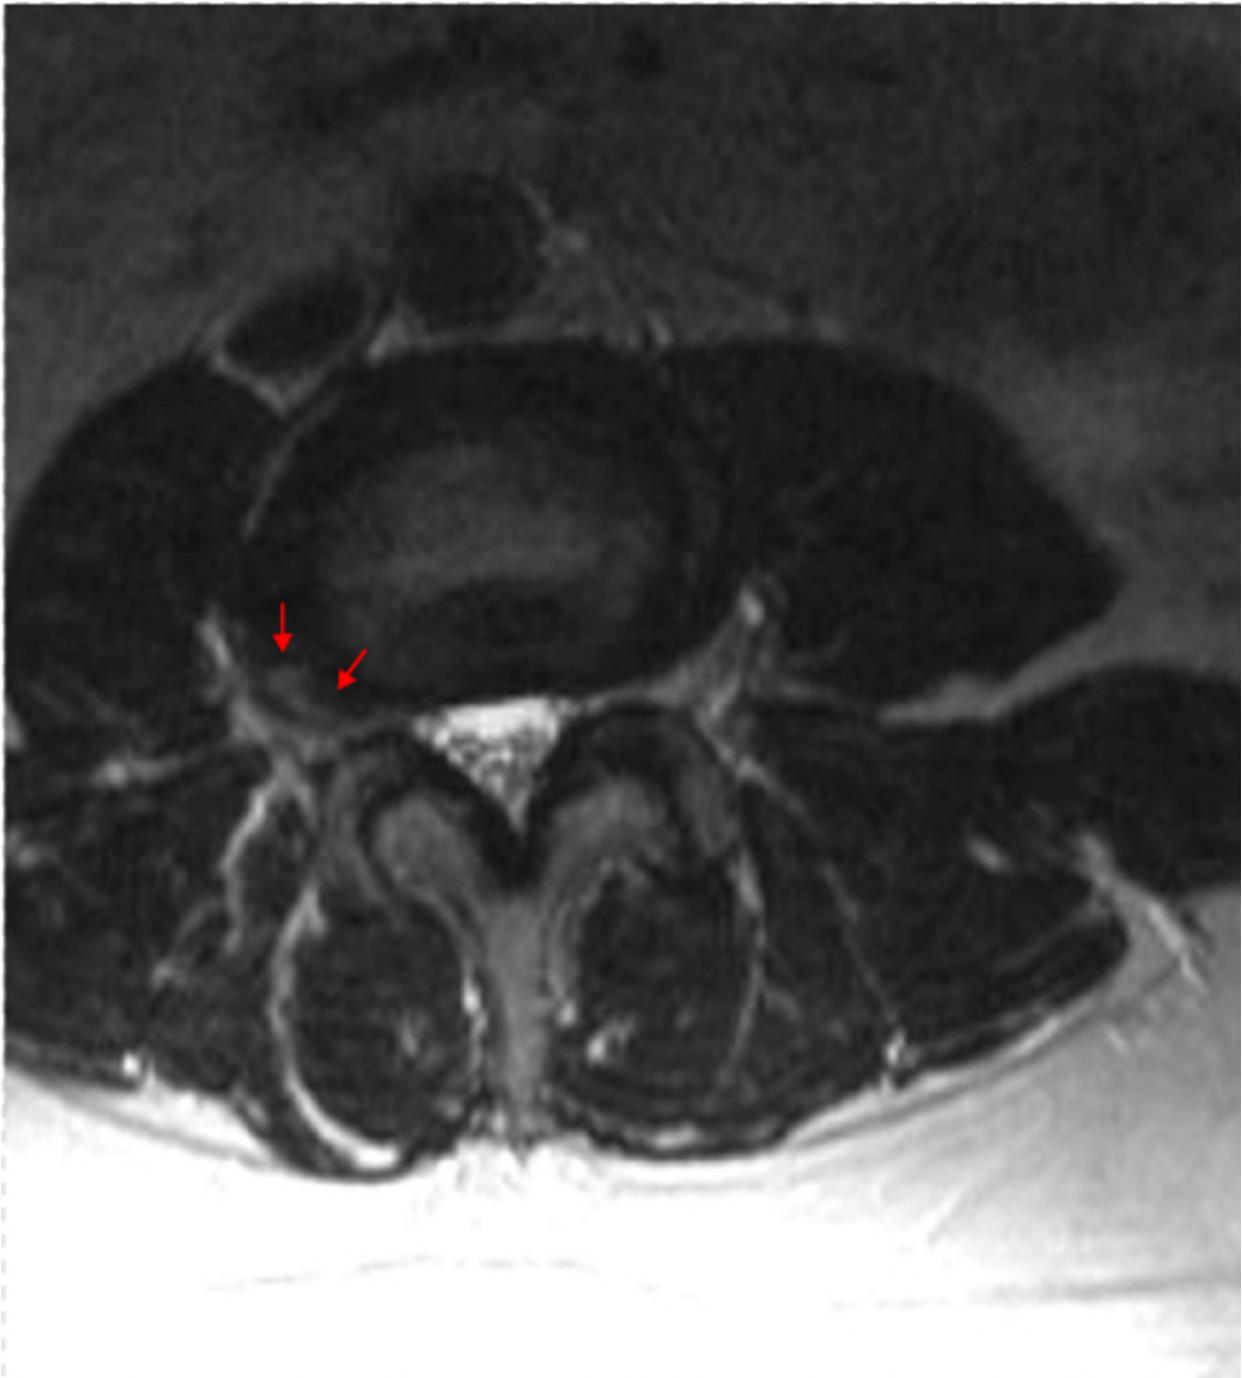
Axial T2 Weighted Lumbar Spine MRI. Right Foraminal Disc Herniation
